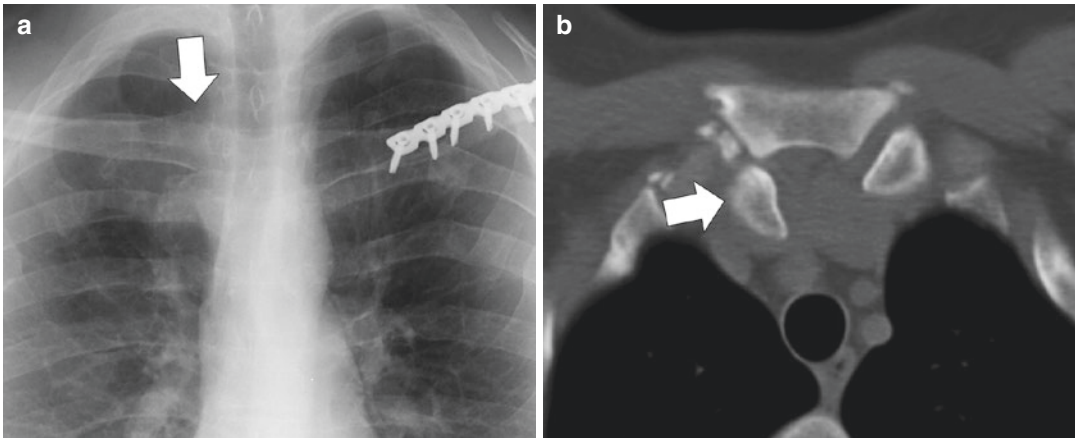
Sternoclavicular joint (SC) separation. (a) Frontal radiograph of the chest shows asymmetric elevation of the right clavicular head (arrow) compared to the left. (b) Axial CT image shows that the asymmetry is
